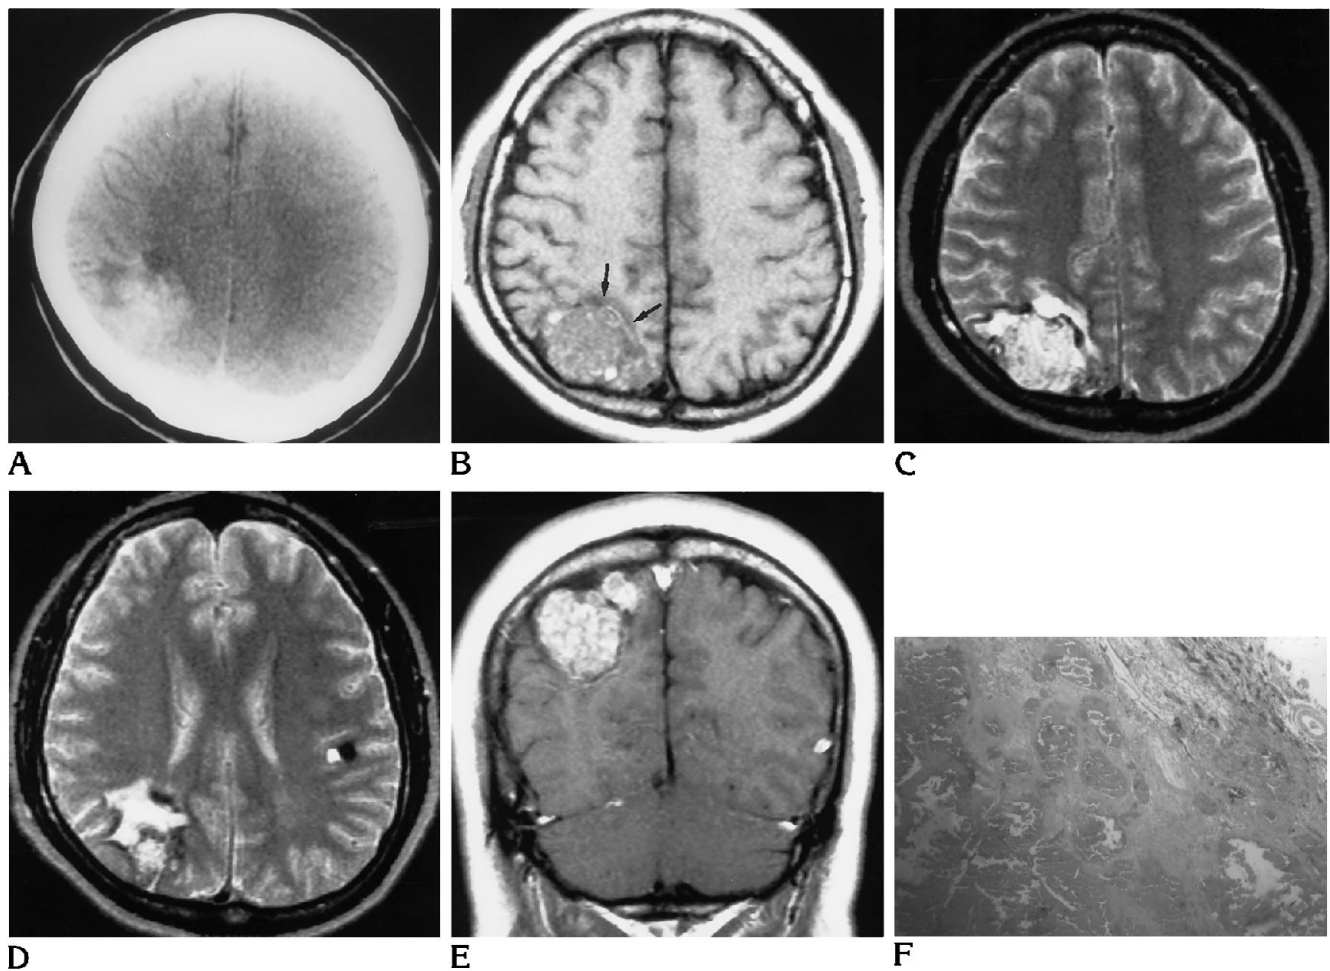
A, Plain CT shows a hyperdense mass in the right posterior parietal region. The mass contains some punctate calcifications, and there is low density in the adjacent brain anterior to the lesion.
